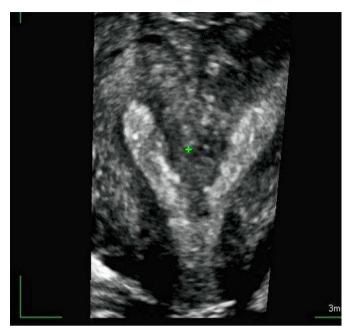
A septate uterus on 3D ultrasound.
